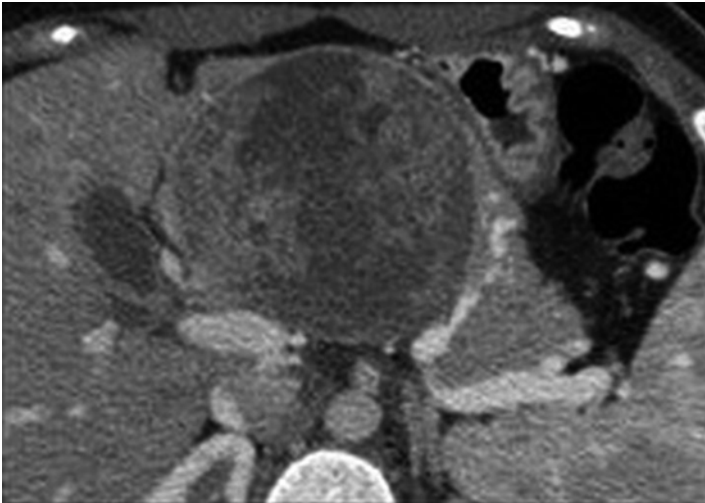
MRI showing a large complex cystic SPN
